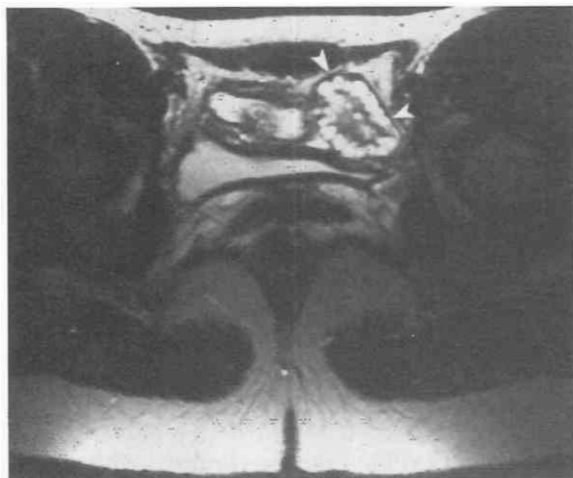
Polycystic ovarian syndrome in a 29-year-old woman. Axial T2-weighted, fast spin-echo image (TR = 4000 msec, TE_{eff} = 126 msec) shows a left ovary with innumerable high-signal-intensity peripheral cysts surrounded by a slightly thickened low-signal-intensity tunica (arrowheads). TE_{eff}, effective echo time.
